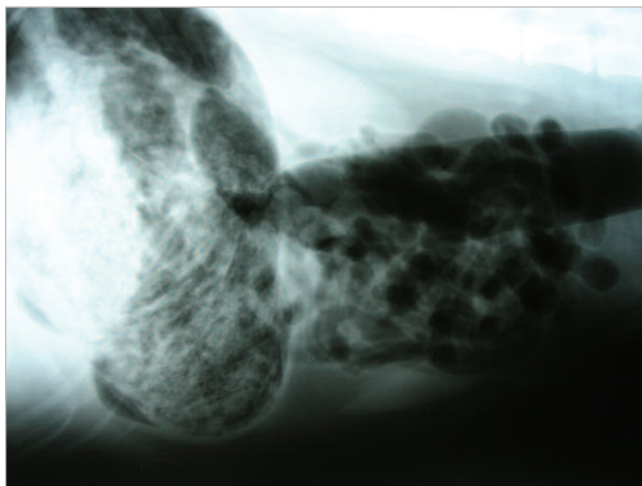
Radiograph showing a distended colon and large amount of foreign material that is impacting the stomach. During surgery, the foreign material was revealed to be 5 lb (2.3 kg) of ivy.
